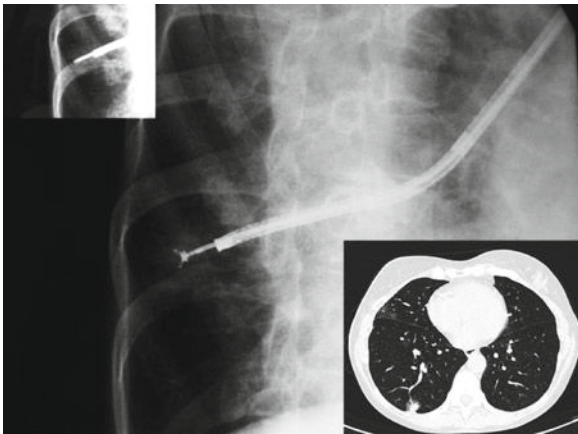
A 47-year-old patient presented with fever and elevated liver enzymes 4 months after allogeneic BMT for relapsing AML. He was receiving steroids for acute GVHD (isolated skin involvement for 3 weeks). Liver biopsy was diagnostic of uncontrolled GVHD, and immunosuppressants were increased. CT was diagnostic of an isolated pulmonary nodule. Sputa examinations as well as BAL fluid analysis were negative. Invasive pulmonary aspergillosis was confirmed by trans-bronchial biopsy
